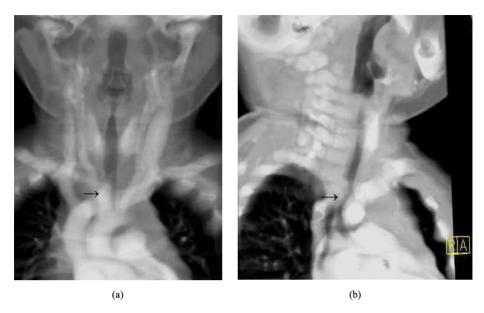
S-CT, thick MPR reconstruction: Tracheal compression caused by the brachiocephalic artery (marked by black arrow). (a) shows an ap-view, and (b) a lateral view. On both views the tracheal compression can be percepted.
